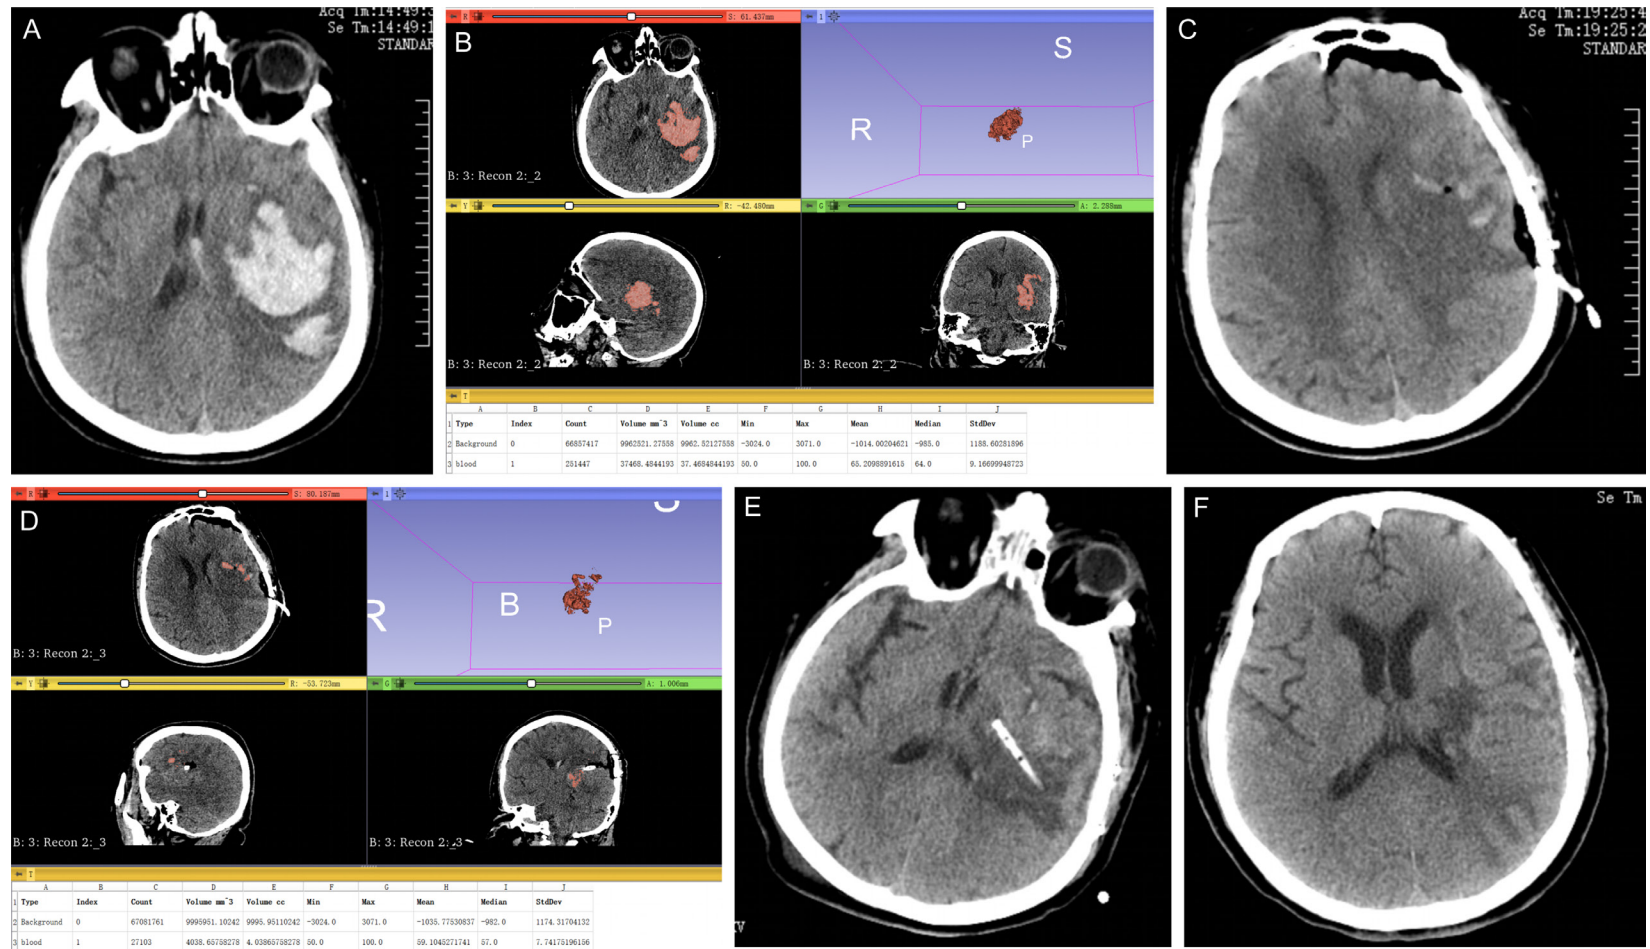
Neuroendoscopic surgery (ICH in the basal ganglia region). A. Preoperative head CT, cerebral hemorrhage in the left basal ganglia area. B. The hematoma volume calculated by 3D-Slicer. C. The head CT was reexamined on the day after operation, and the intracranial hematoma was cleared. D. The hematoma volume calculated by 3D-Slicer after operation, and the hematoma evacuation rate was $86.25 \pm 2.27\%$. E. Reexamination one week after operation CT showed that intracranial drainage tube was observed. F. CT scan one month after operation revealed that the hematoma was completely absorbed.
